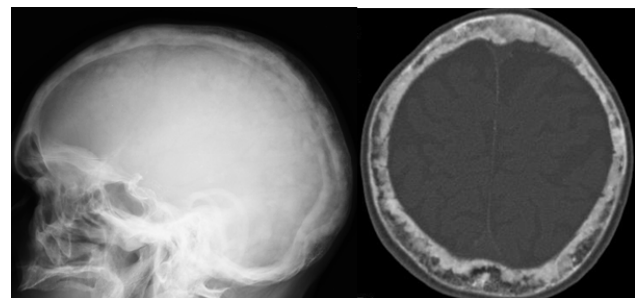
Skull x-ray profile view (left). Skull CT bone window (right). Diffuse calvaria Paget's disease
